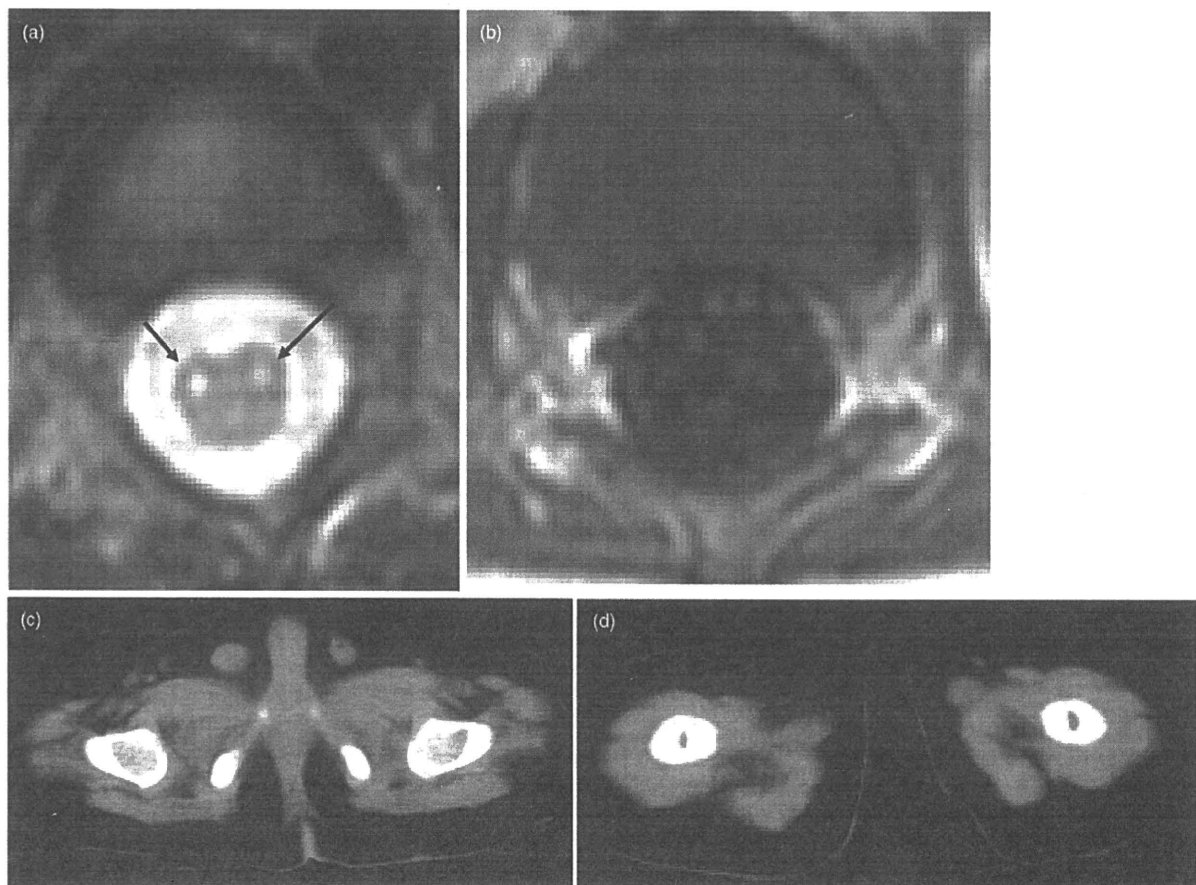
Magnetic resonance imaging (MRI) and computed tomography (CT) images taken on day 39 of illness. (a) Axial image of T2-weighted MRI demonstrating bilateral high-intensity signals (arrows) in the anterior spinal cord at the level of T11. (b) Axial image of gadolinium-enhanced T1-weighted MRI demonstrating an enhanced ventral cauda equina. (c) CT images showing severe bilateral muscle atrophy in the gluteus and (d) femoral muscles.
